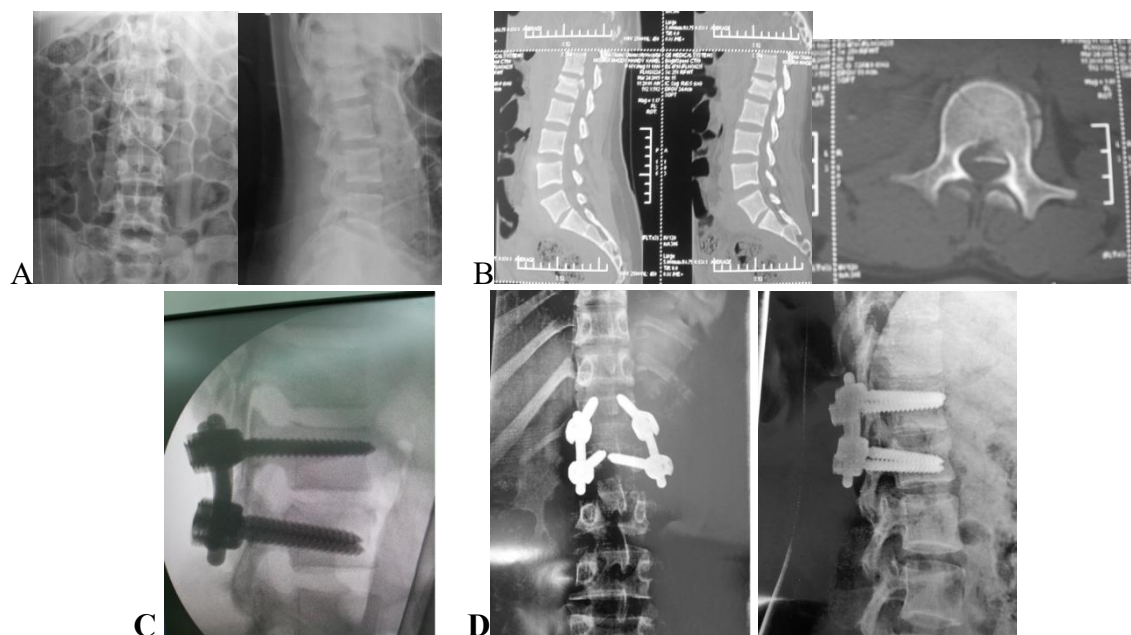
L1 burst fracture classified as A3.1 in Female patient, 17 years old, house wife as a result of Falling from height. (A) Preoperative anteroposterior and lateral radiograph. (B) Preoperative thoracolumbar spine computed tomography sagittal and axial images. (C) images initial Postoperative lateral radiograph. (D) One year follow-up anteroposterior and lateral radiograph.
